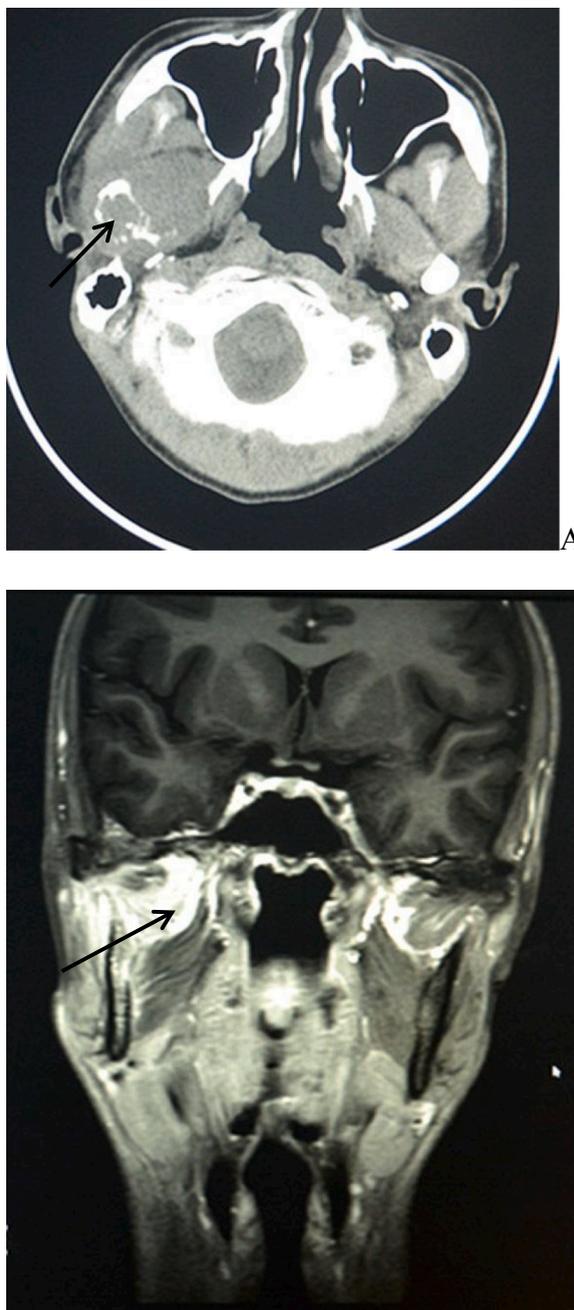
(A) Lytic destruction and swollen soft tissue; (B) hyperintensity on T2-weighted imaging as diffuse increase.
